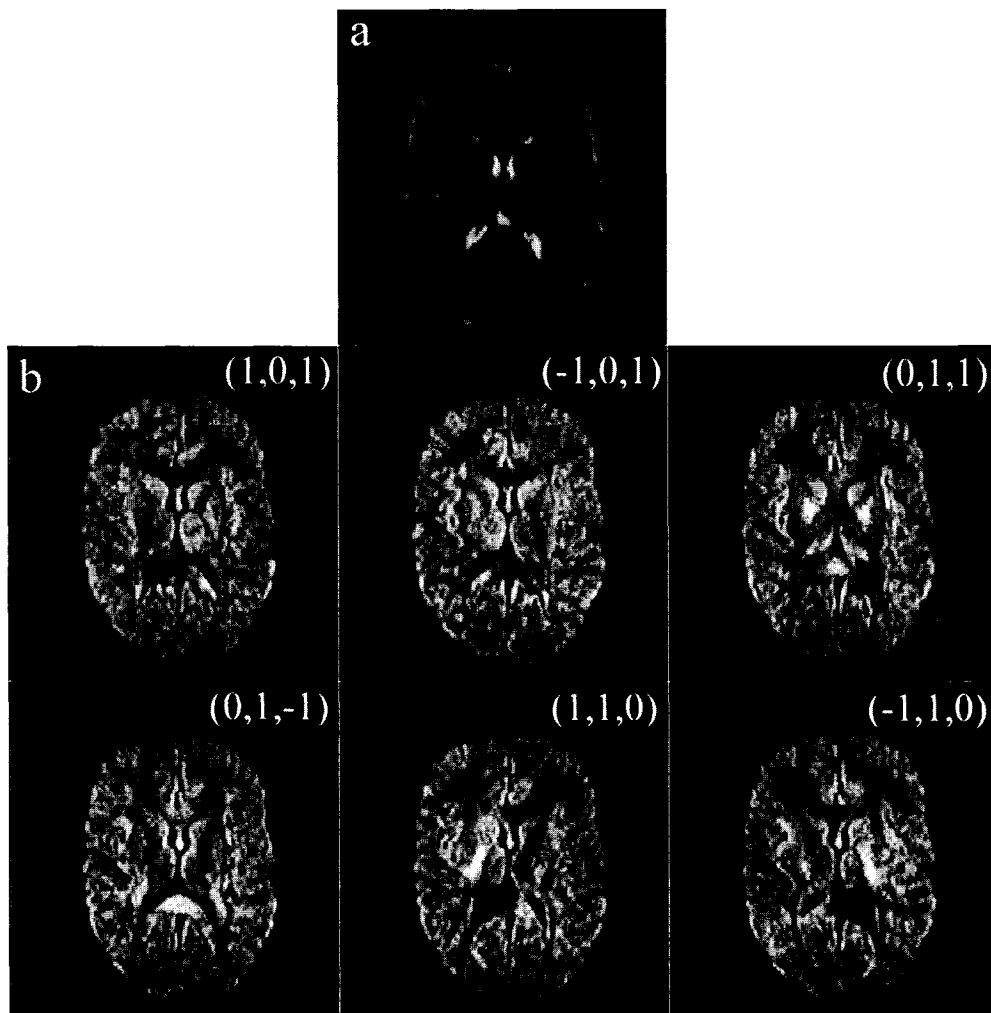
Raw DWI images for a 22 year old male subject. a) $b = 0 \text{ s/mm}^2$, b) all six images at $b = 1000 \text{ s/mm}^2$, with diffusion gradient directions marked in top right corner.
